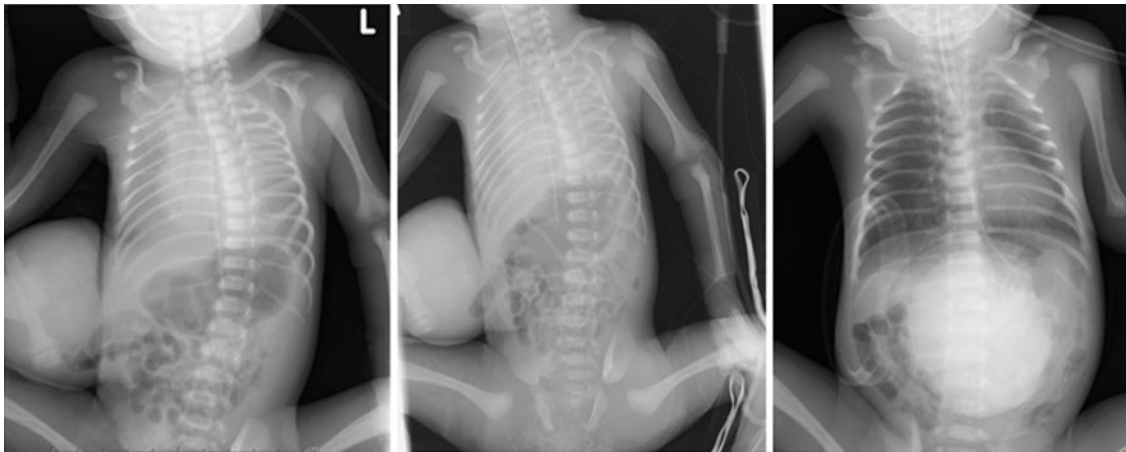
Chest radiography before (*left*) and after induction of anesthesia (*middle*) and on the day following surgery (*right*). Two hours after birth there was a decreased permeability in the lung fields. After induction of anesthesia, the permeability of the lungs was markedly
